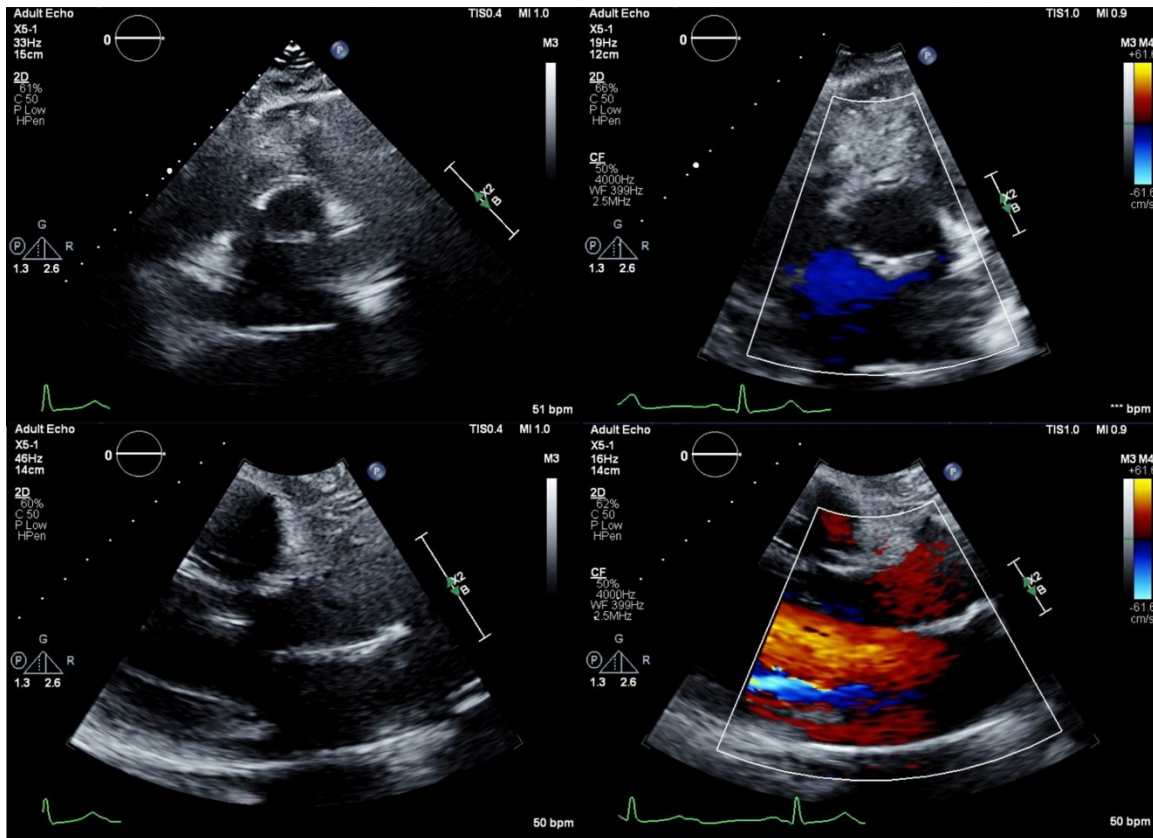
Transthoracic echocardiographic images obtained post-TAVR. Top Left: Parasternal short axis. Top Right: Parasternal short axis with color showing no AR. Bottom Left: Parasternal long axis. Bottom Right: Parasternal long axis with color showing no AR.
